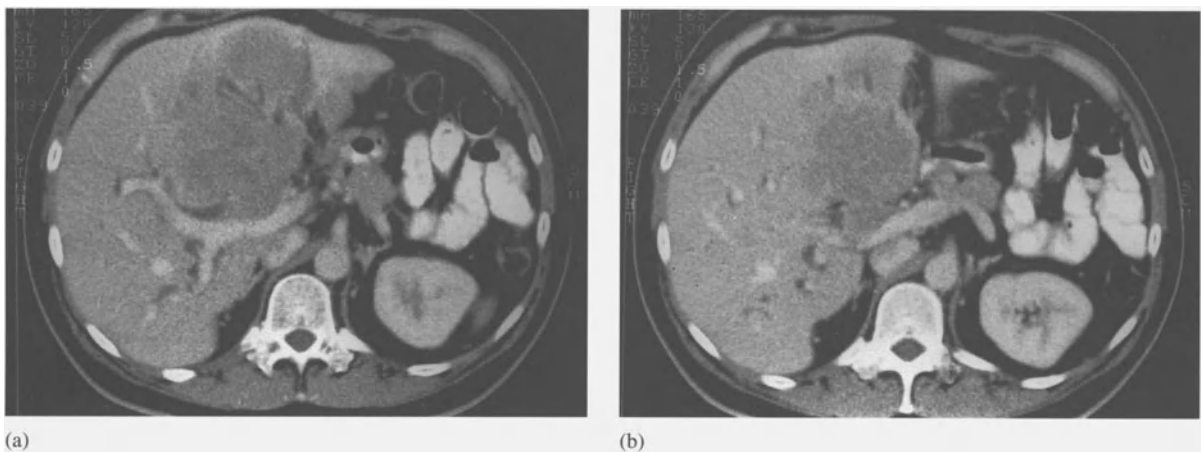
a and b Targeted 24-second spiral acquisition of the liver dome region using 5 mm/s table feed speed, 5-mm collimation and 3-mm reconstruction increment. The study depicts a haemangioma in a location often difficult to image completely with conventional CT due to respiratory misregistration
